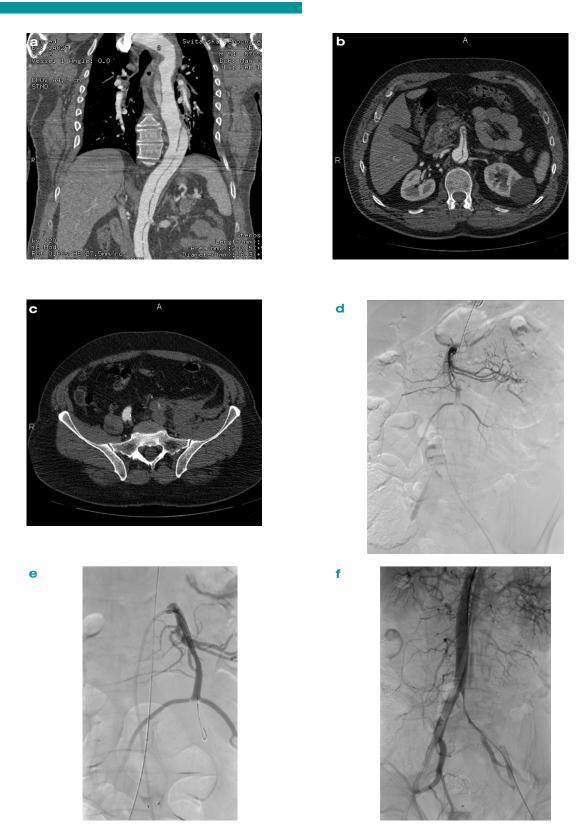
55 year old man with acute complicated aortic dissection type B. Pre-operative CT shows the extent of dissection from LSA to the pelvic arteries (a). Dissection also affected the trunk of the superior mesenteric artery (SMA) and left common iliac artery (CIA) and caused their static occlusion (b,c). Endovascular therapy consists of the thoracic stent graft insertion and AMS (d,e) and left CIA stenting (f,g). Follow-up CT confirms good patency of stented arteries and exclusion of the false lumen at the level of stent graft (h).
